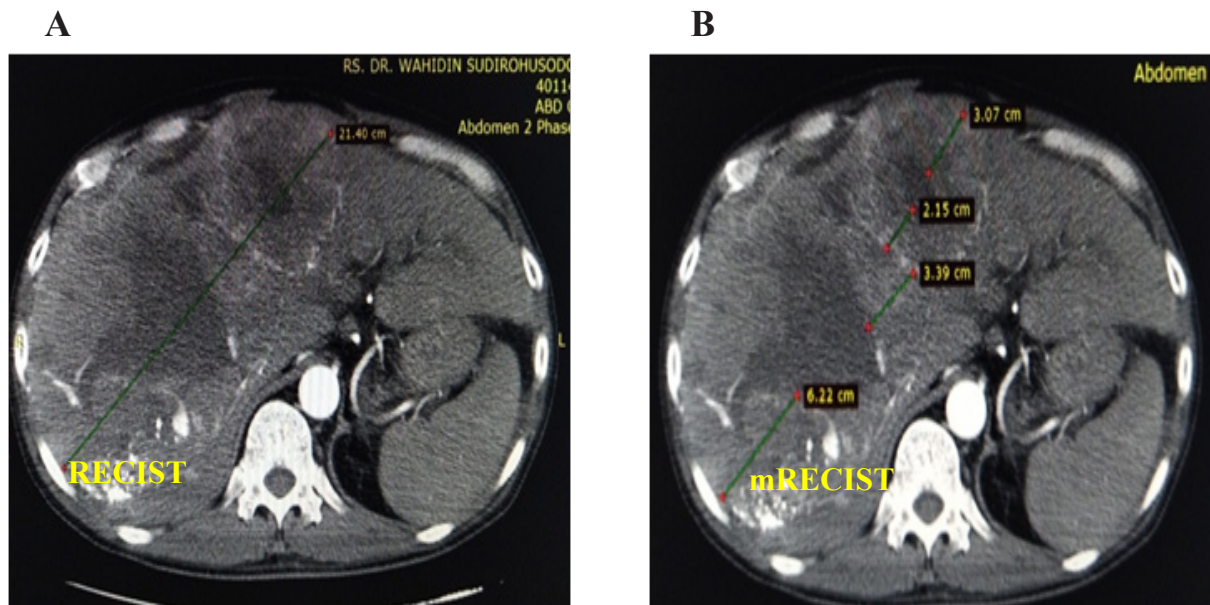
Assessment of target lesions on the axial cut of multiphase abdominal CT using RECIST vs. mRECIST method. A. The total diameter of target lesions obtained from the sum of the longest tumor axis. B. The total diameter was obtained from the sum of the longest tumor axis outside the area of necrosis
